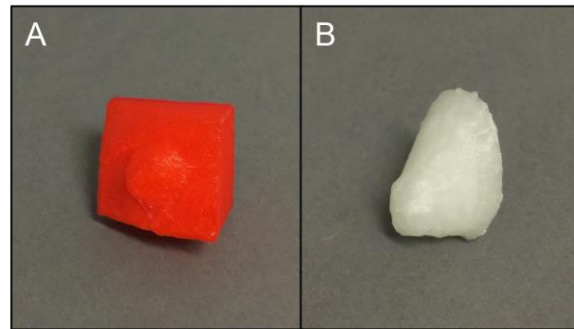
A 3D-printed biomodel of nipple using (A) CT and (B) MRI scans. Printing performed using Moment 3D printer (Moment, Seoul, South Korea) and 3D Slicer.
